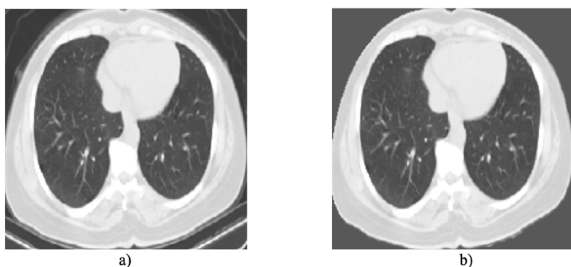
A chest CT scan before (a) and after (b) the replacement of noise from external features with a background mean.
